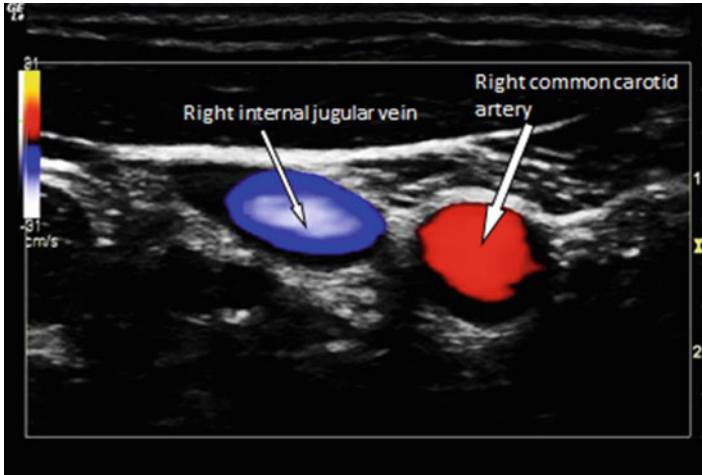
Transverse view showing the right common carotid artery (RCCA) and the right internal jugular vein (RIJV) with color Doppler box superimposed over the vessels
